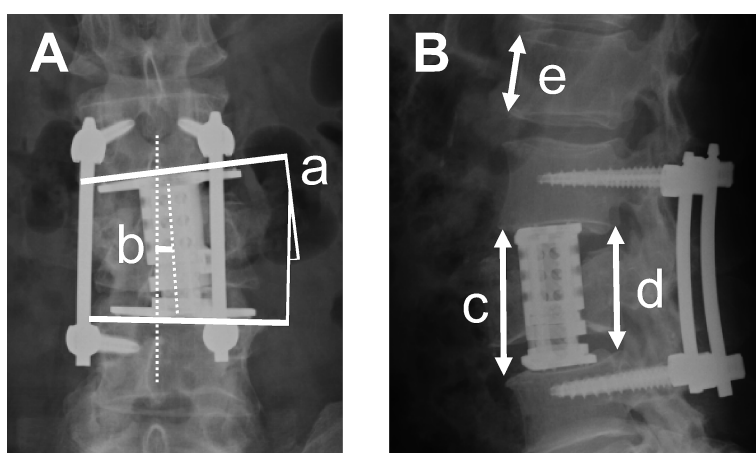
Measurement on radiographs
